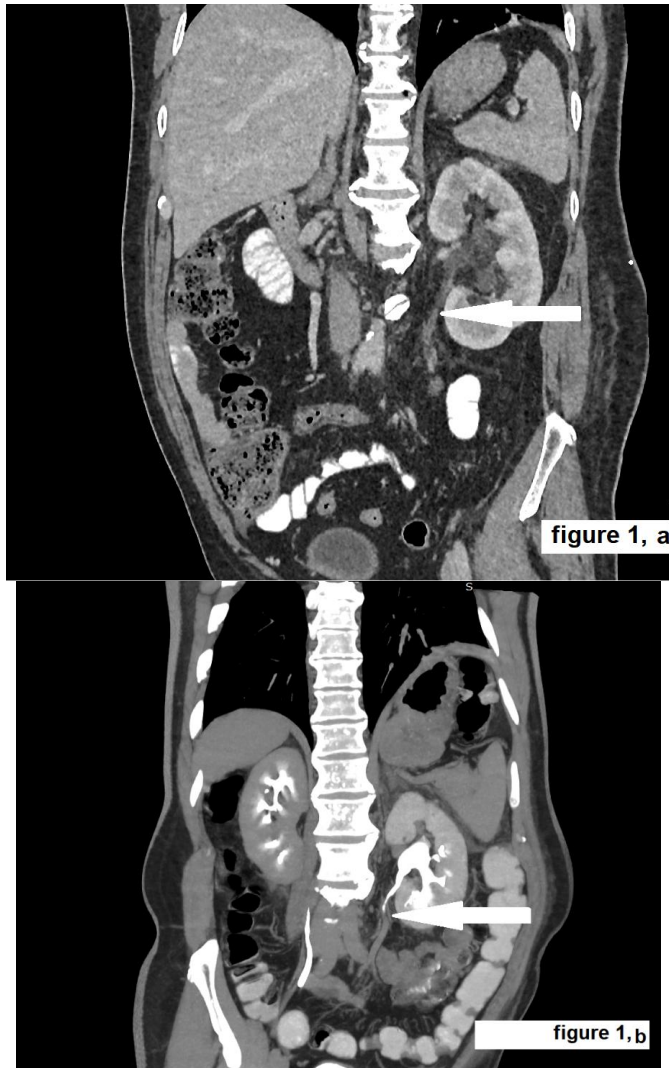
(a, b) Triphasic urinary tract computed tomographic scan (CT) (a) An area of ureteric wall enhancement detected (arrowed) without evidence of adjacent masses or enlarged lymph nodes, (b) delayed images showed complete ureteral obstruction a few centimeters distal to the pelviureteric junction (arrowed)
